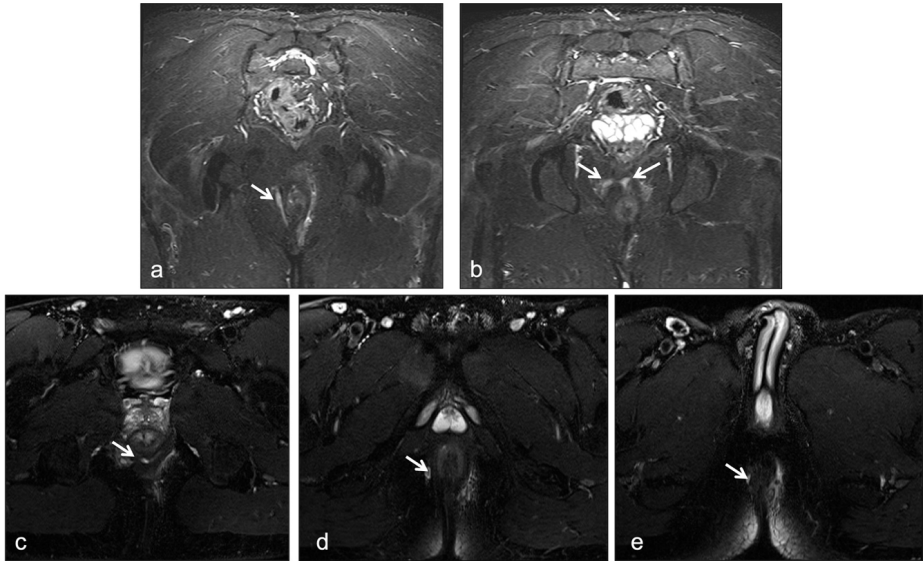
Suprasphincteric fistula, 37 year old male patient, 1,5T perianal MR imaging with i.v. contrast media injection. a. and b. coronal T2W FS images, linear hyperintense fistula tract extends superiorly in the intersphincteric space c, d and e. tractus ascends and opens to the skin.
